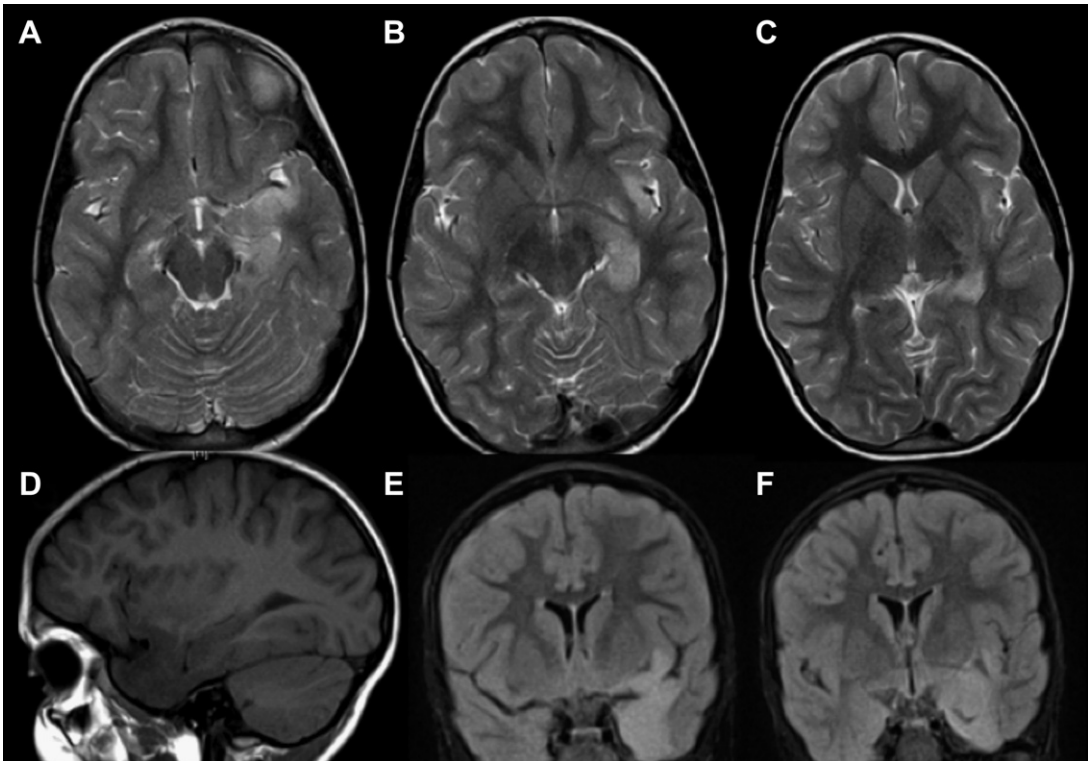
Axial (A–C), sagittal (D), and coronal (E, F) MR images of left temporal low-grade glioma showing tumor extension through the temporal stem into the region of the external and extreme capsules and inferior frontal region.
